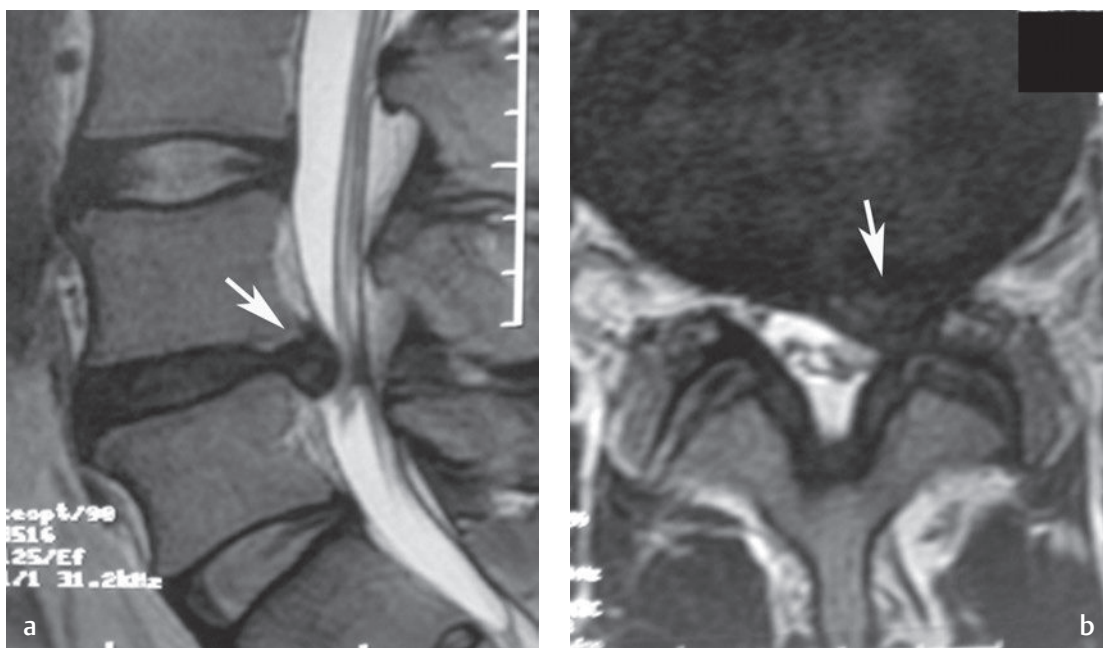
Traversing nerve root impingement. (a) A sagittal T2-weighted image shows L4-L5 disc protrusion (arrow). (b) At the level of the L4-L5 disc, this axial T2-weighted image shows a left central/subarticular disc protrusion (arrow) contacting the traversing left L5 nerve root in the left lateral recess. This patient presented with numbness in the first web spaces of the left foot and diminished strength with hip abduction and great toe extension.[†]
